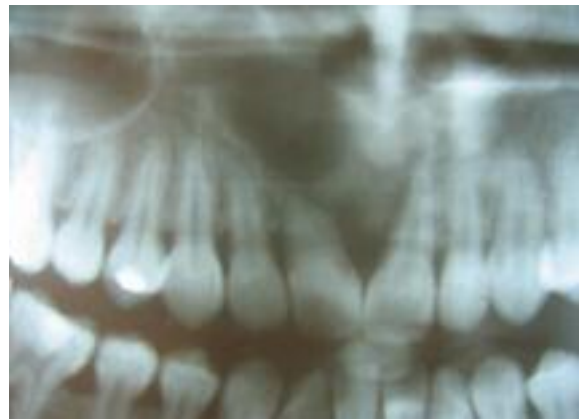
The region of the lesion on panoramic radiography.
